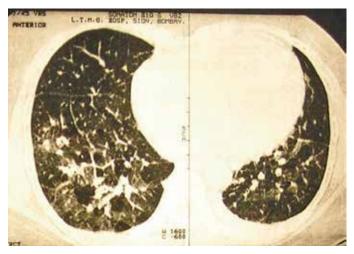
HRCT chest of case 2, Ground glass opacities and fibrosis
